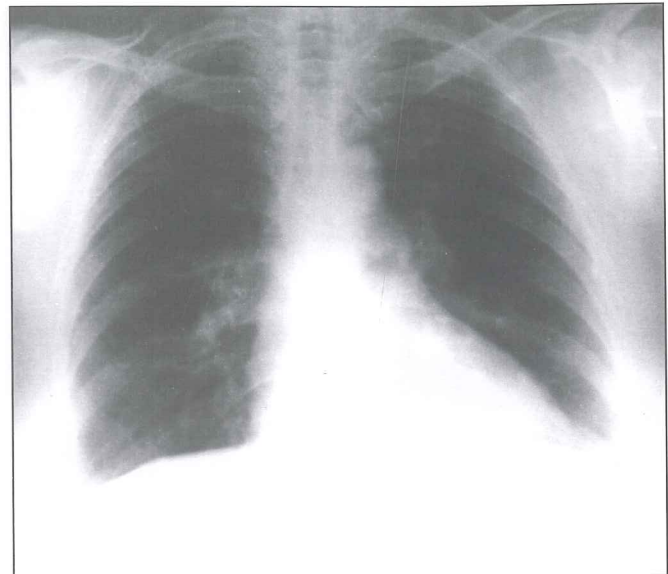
Chest X-ray of the patient at the end of corticosteroid therapy.
